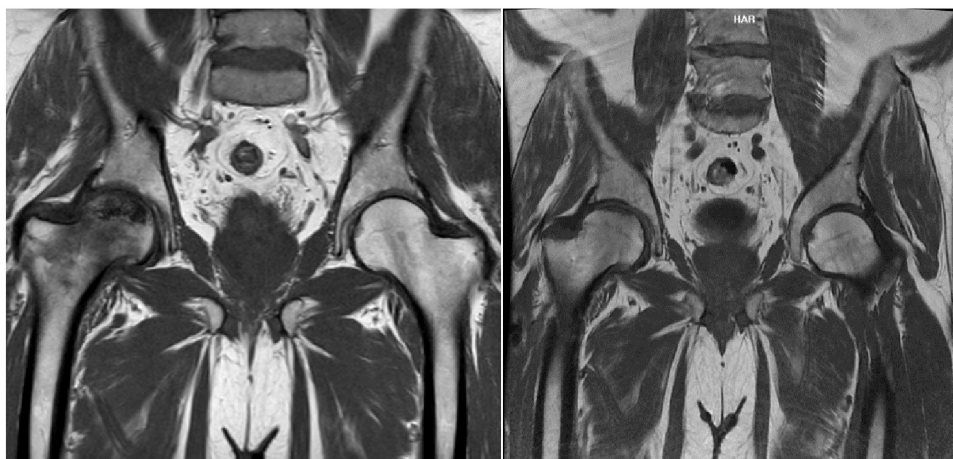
On the left T1 MRI weighted coronal image of the hips preoperatively and on the right 3 months postoperatively.
